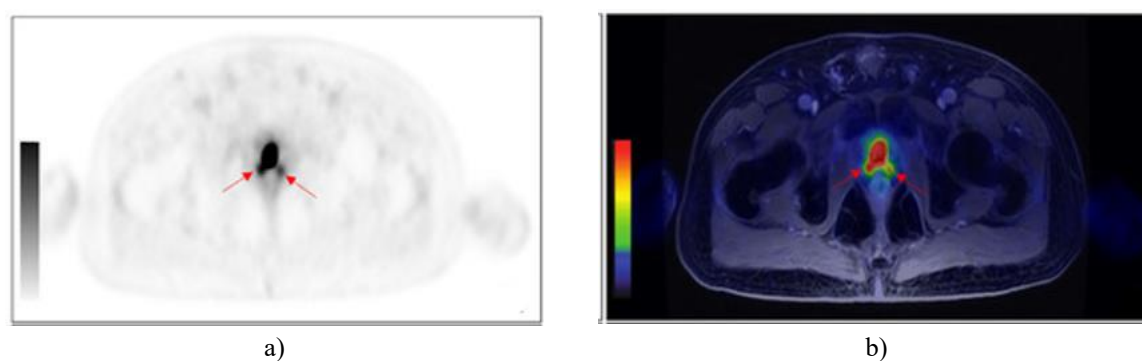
Example of Concordant PET/MRI Findings in Lymph Node Recurrence
